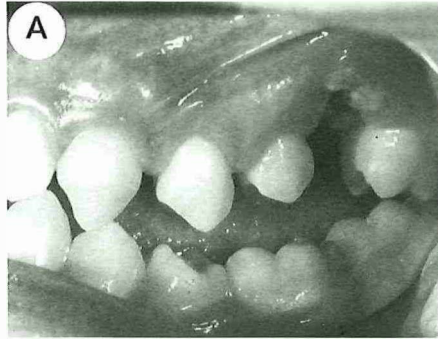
A Clinical view of the maxilla of a 14-year-old girl showing secondary retention of the left first molar. B Orthopantomogram of the same patient showing the position of the retained molar and reduction of height of the alveolar process in the relevant area. Note the presence of a restoration in the crown, indicating that the molar once was in occlusion.
